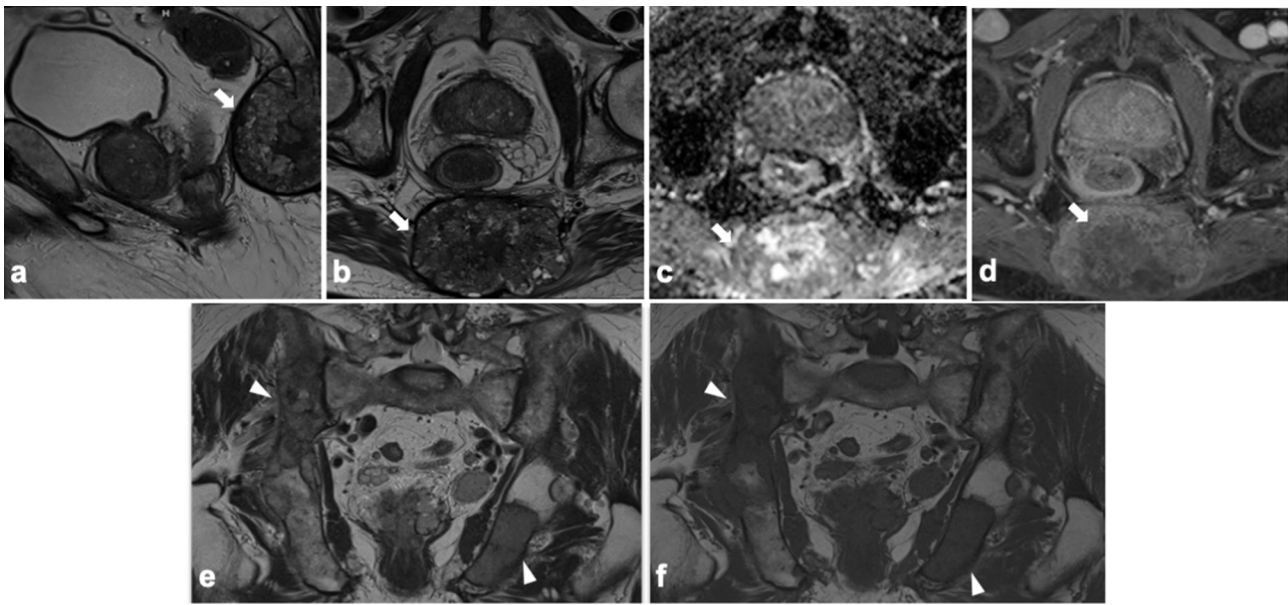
A large destructive bony mass lesion (arrows) centered upon the coccyx and the fifth sacral vertebra, with inhomogeneous low signal on sagittal (a) and axial (b) T2w images, mostly peripheral restricted diffusion on ADC map (c), heterogeneous enhancement on axial DCE image (d) and extra-osseous extension is shown; the lesion was confirmed at biopsy as sacrococcygeal chordoma. Coronal T2w (e) and T1w (f) images show multiple hypointense lesions localized at pelvic bones (arrowheads), in keeping with metastases. T2w T2-weighted, ADC apparent diffusion coefficient, DCE dynamic contrast enhanced, T1w T1-weighted.
